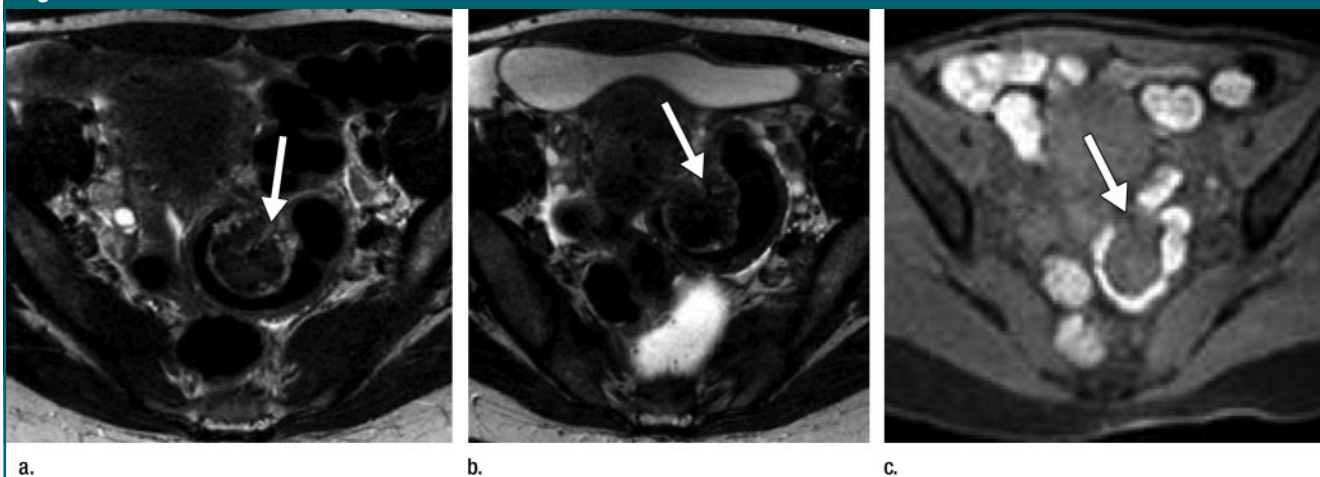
(a) Axial T2-weighted MR image (repetition time, respiratory period; echo time, 135 msec) obtained before rectal filling with US gel in 32-year-old woman shows deep endometriosis involving the sigmoid colon with a bulging lesion (arrow). At both MR imaging and pathologic examination, the colon wall infiltration was graded as involving the muscularis layer. (b) Axial T2-weighted MR image (repetition time, respiratory period; echo time, 135 msec) obtained after rectal filling with US gel. The gel is visible in the rectum but did not reach the sigmoid level. The same lesion (arrow) is seen. (c) On axial breath-hold three-dimensional fat-suppressed T1-weighted MR image (3.3/1.65; flip angle, 10°), the rectosigmoid contents appear hyperintense (arrow) and provide good depiction of the lesion boundaries without administration of intrarectal US gel.
